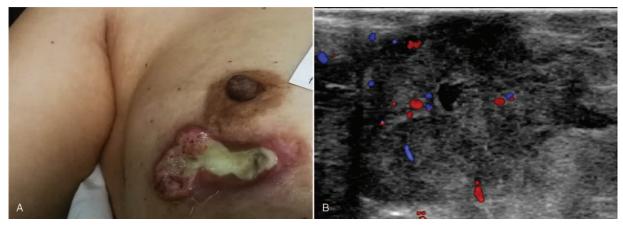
A: skin ulceration and oozing with fluid. B: Ultrasound examination showed a nearly solid lesion with blood flow signal in the solid component.
